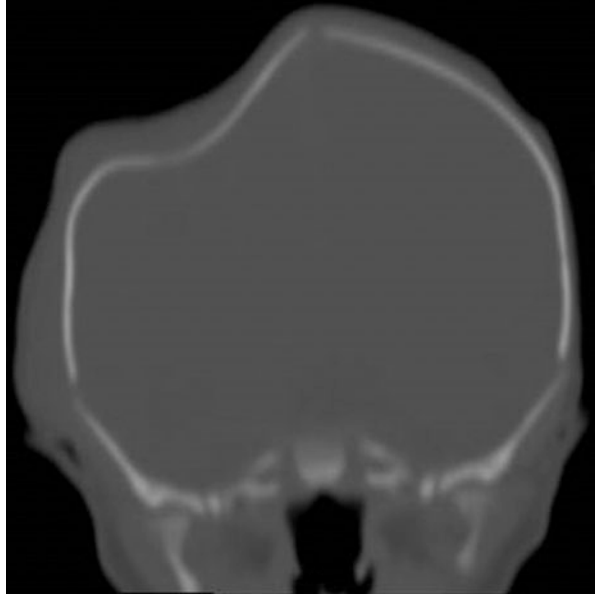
3D reconstruction CT brain for neonate with right parietal ping pong fracture
